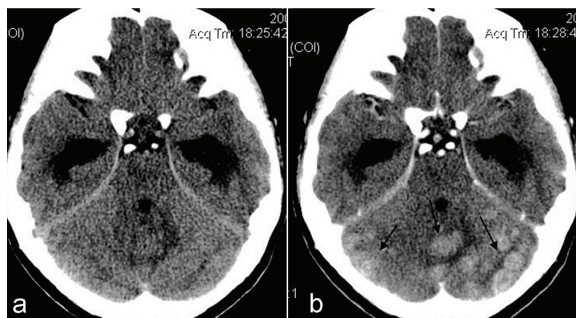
A 47 year-old-woman with brain metastasis. a) NCCT and b) contrast enhanced CT (CECT) scans showed multiple small enhancing isoattenuating nodules at bilateral cerebellar hemispheres (arrows) with obstructive hydrocephalus.
